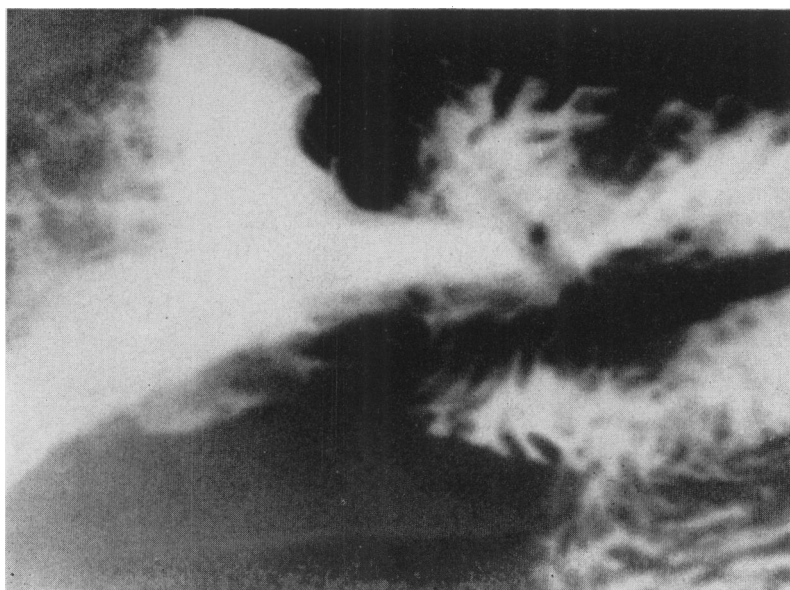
X-ray film showing complete disappearance of gastrojejunal ulcer crater 47 days after transthoracic vagotomy.
